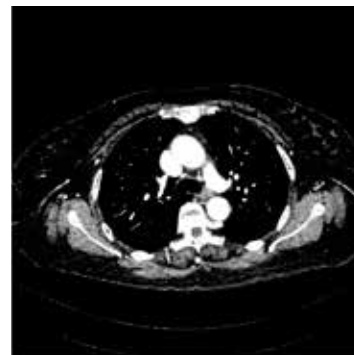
(a) Volume rendering image of the oblique anterior view shows the overall view of the hemiazygos system where the hemiazygos vein connects to the superior intercostal vein. SVC: superior vena cava, LBCV: left brachiocephalic vein, LRV: left renal vein, GV: gonadal vein, purple vessels: hemiazygos, intercostal and lumbar veins. (b) Partial maximum-intensity projection image shows a mildly dilated left superior intercostal vein. Arterial density of the right brachiocephalic artery and aorta is removed from the image. LSIV: left superior intercostal vein, RBA: right brachiocephalic artery, Ao: aorta. (c) Maximum-intensity projection image of the overall view of the hemiazygos system. White arrowheads show the hemiazygos vein. LIJV: left internal jugular vein, LSIV: left superior intercostal vein, LRV: left renal vein, GV: gonadal vein. (d) Axial contrast-enhanced CT image (1-mm slice thickness, 70 keV) shows the absence of the azygos arch (asterisk). (e) Sagittal image shows the first lumbar vein (black arrow) and the second lumbar vein (white arrow). No ascending lumbar vein between the first and second lumbar veins. The subcostal vein (black arrowhead) connects to the hemiazygos vein (white arrowheads).
